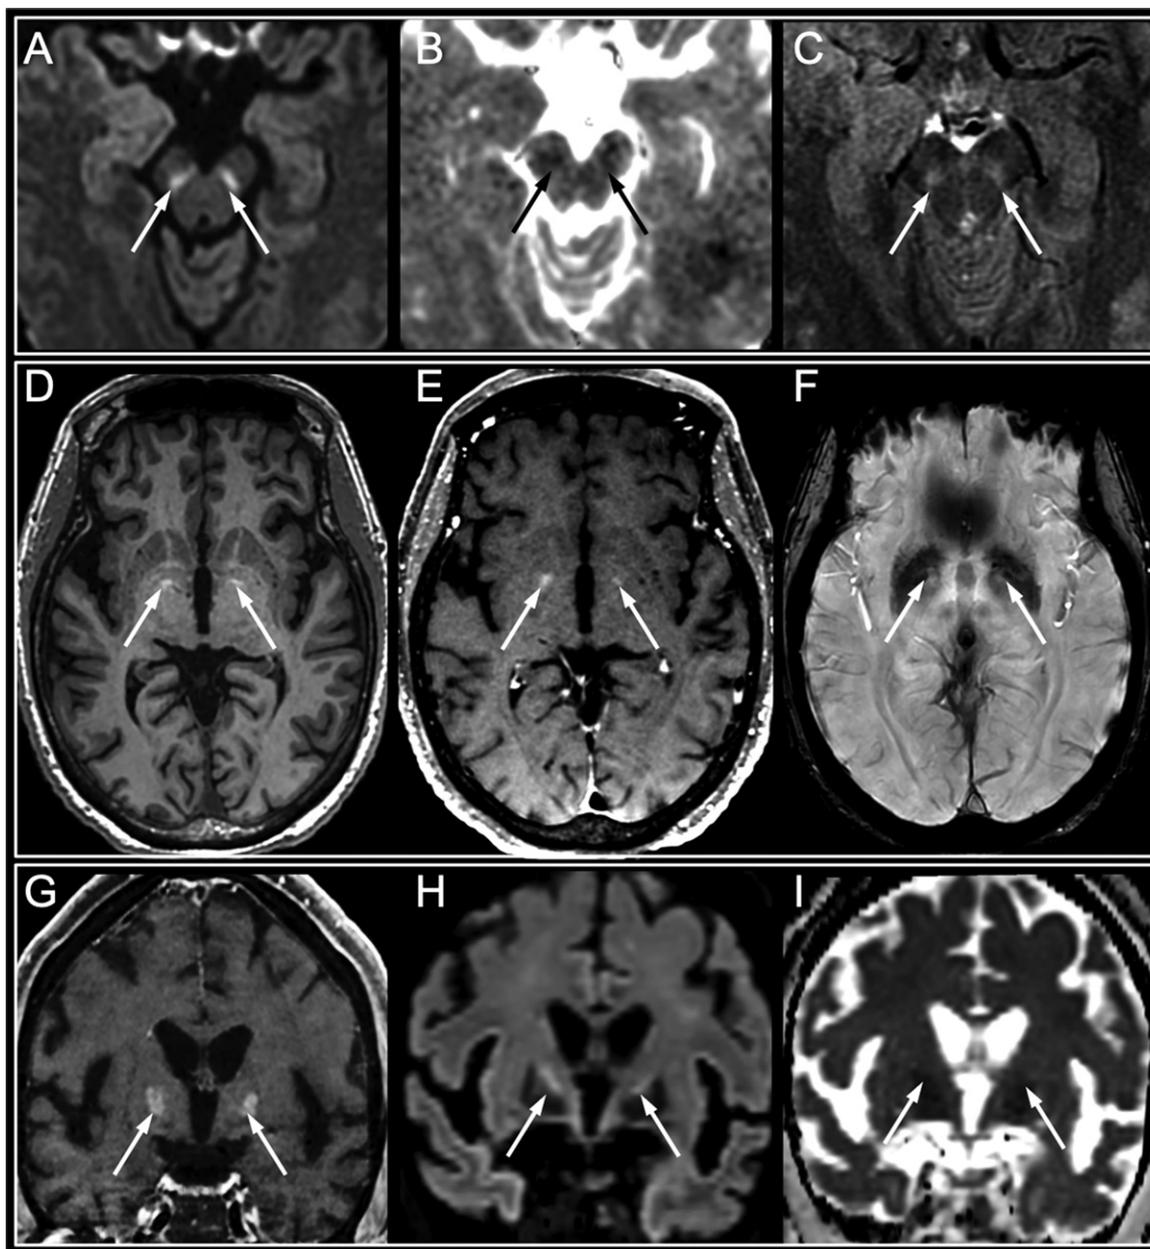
Basal ganglia abnormalities in three patients who experienced late awakening after withdrawal of sedation in the context of severe acute respiratory syndrome coronavirus 2 hypoxic pneumonia with severe acute respiratory syndrome. A–C, Images in a 42-year-old man with untreated chronic lymphocytic leukemia who had tetraparesis upon awakening after 47 days of intensive care. Hyperintensity within the substantia nigra on a diffusion-weighted image (arrows in A) with decreased apparent diffusion coefficient (arrows in B) and hyperintensity on axial fluid-attenuated inversion recovery images (arrows in C) were visible. The follow-up neurologic examination showed complete consciousness recovery with persistent peripheral motor deficit consistent and mild parkinsonian symptoms. D–F, Images in a 62-year-old woman with diabetes and chronic cardiovascular disease who experienced cardiorespiratory arrest after 54 days of intensive care. Hyperintensity on precontrast magnetization-prepared rapid acquisition with gradient-recalled echo axial T1-weighted images in the globus pallidus (arrows in D) with no enhancement on postcontrast T1-weighted images (arrows in E) or hypointensity on susceptibility-weighted images (arrows in F). The follow-up neurologic examination also showed complete consciousness recovery with a persistent motor deficit. G–I, Images in a 56-year-old woman with diabetes and obesity who experienced late awakening after 48 days of intensive care. Bilateral enhancement within the globus pallidus on coronal postcontrast T1-weighted images (arrows in G), with hyperintensity on diffusion-weighted images (arrows in H), and decreased apparent diffusion coefficient (arrows in I). No follow-up was available.
